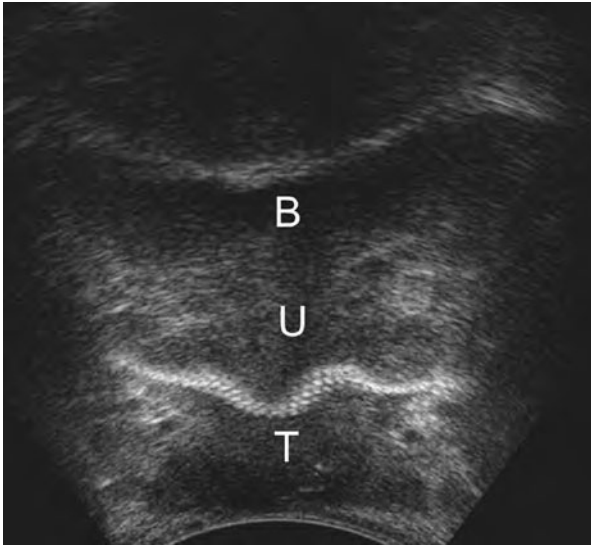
Two-dimensional transperineal ultrasonography. Midurethra (*U*) tape (*T*). *B*, bladder
